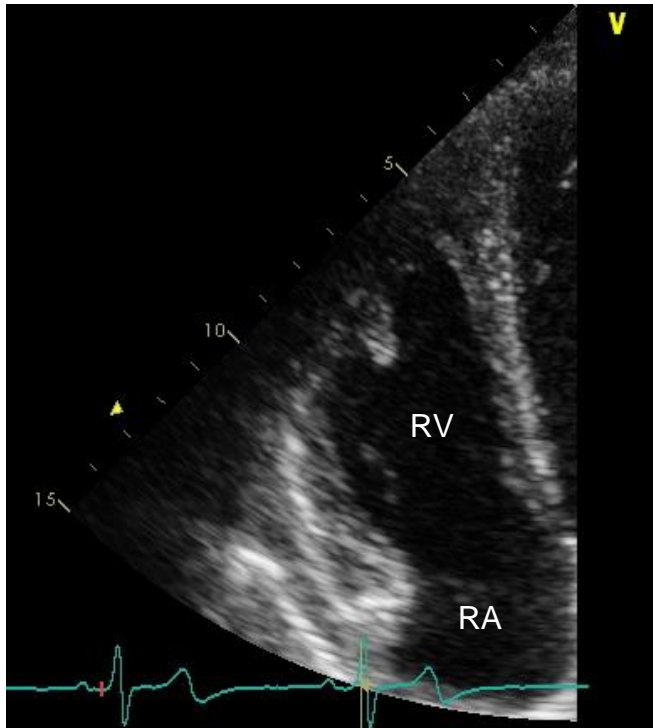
Focused RV view optimised for RV assessment from the apical four chamber view and the inflow components.
